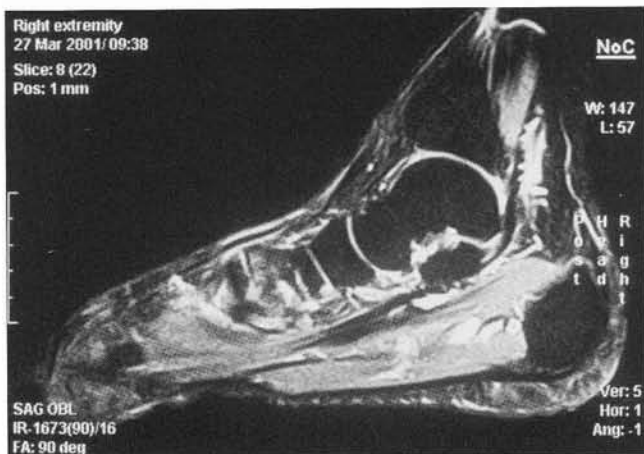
Lateral T2-weighted image of posterior tibial tendon.
